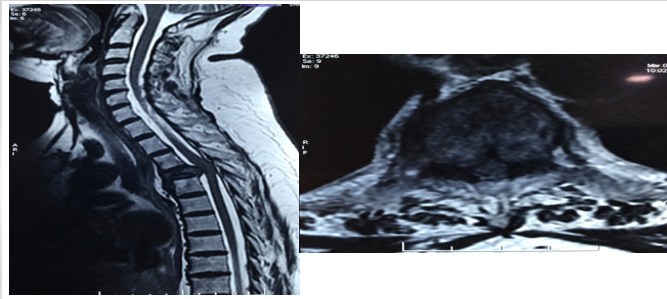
MRI T2 sagittal & axial mages showing T4 level pathological fracture with spinal cord compression
